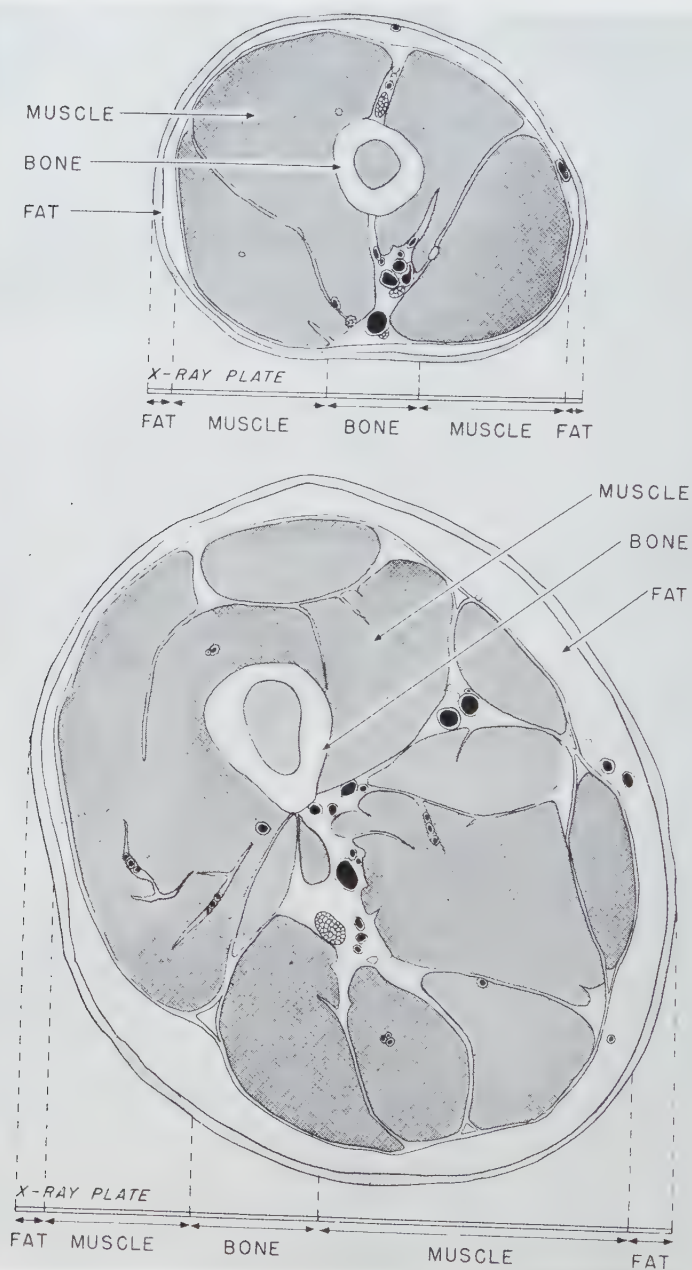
Cross sections of the arm and thigh compared to X-ray views.
